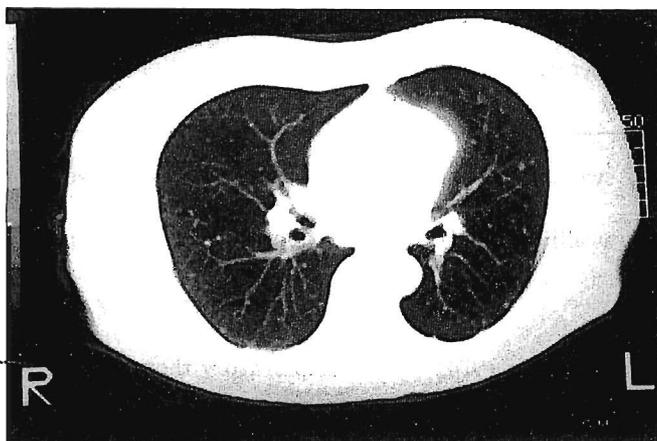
Chest CT scan showing miliary shadows in bilateral lung level. It is difficult to make an accurate diagnosis whether they are pm or not.
